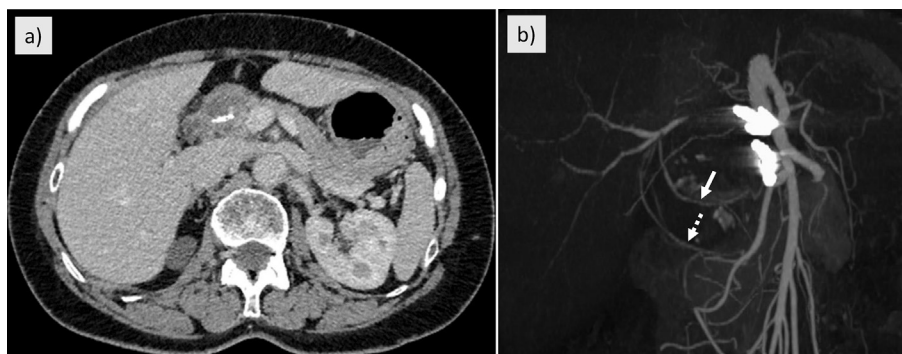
(a) Abdominal enhanced computed tomography one year after treatment showing the hepatic artery aneurysm diameter reduced to 3 cm. (b) The white arrow shows the collateral artery from the superior mesenteric artery, and the white dotted arrow shows the collateral artery from the gastroduodenal artery to the right hepatic artery.
